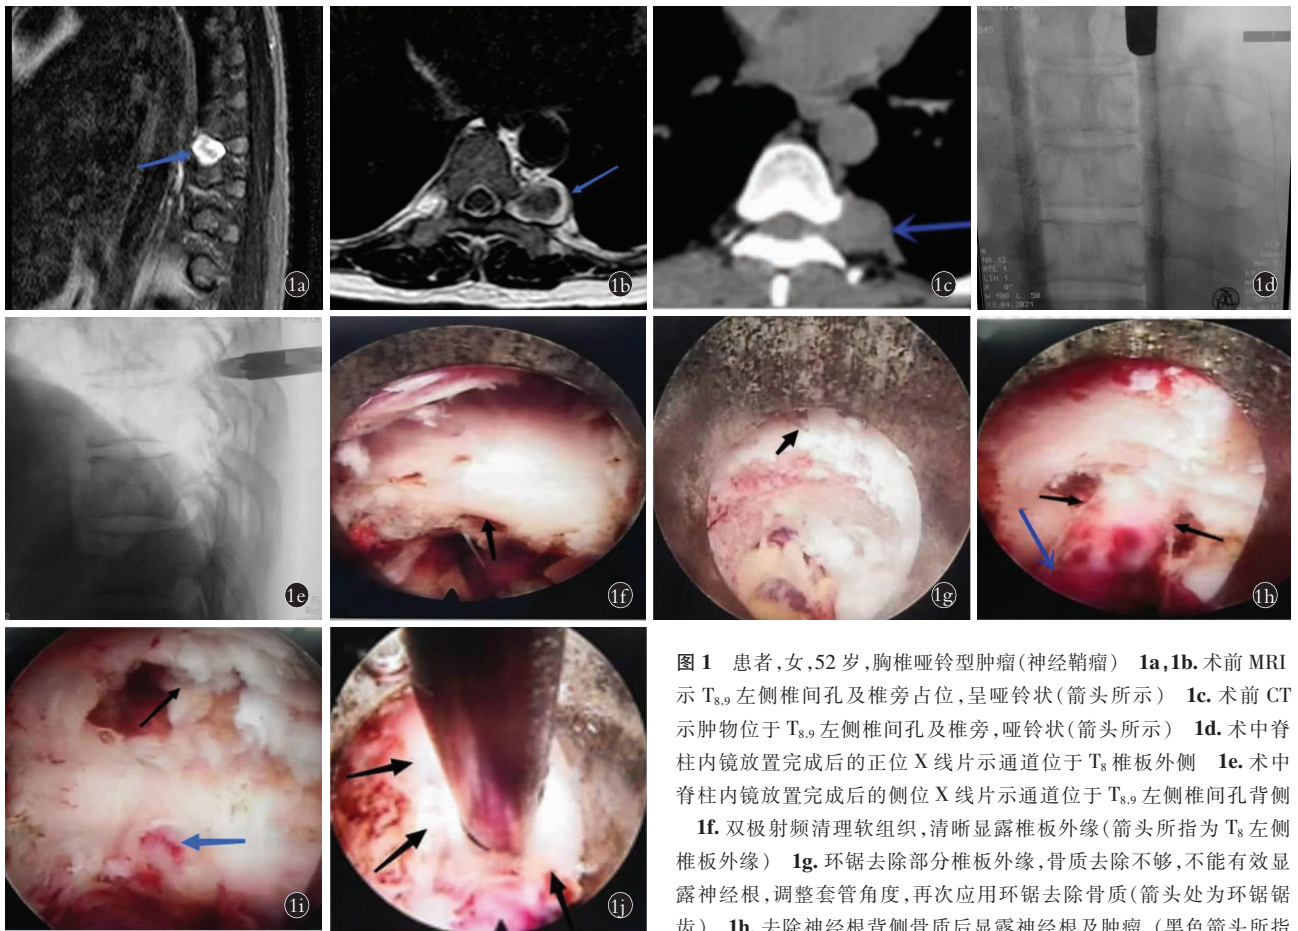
患者,女,52 岁,胸椎哑铃型肿瘤(神经鞘瘤) 1a,1b. 术前 MRI 示 T_{8,9} 左侧椎间孔及椎旁占位,呈哑铃状(箭头所示) 1c. 术前 CT 示肿物位于 T_{8,9} 左侧椎间孔及椎旁,哑铃状(箭头所示) 1d. 术中脊柱内镜放置完成后的正位 X 线片示通道位于 T₈ 椎板外侧 1e. 术中脊柱内镜放置完成后的侧位 X 线片示通道位于 T_{8,9} 左侧椎间孔背侧 1f. 双极射频清理软组织,清晰显露椎板外缘(箭头所指为 T₈ 左侧椎板外缘) 1g. 环锯去除部分椎板外缘,骨质去除不够,不能有效显露神经根,调整套管角度,再次应用环锯去除骨质(箭头处为环锯锯齿) 1h. 去除神经根背侧骨质后显露神经根及肿瘤(黑色箭头所指为神经根,蓝色箭头所指为神经根远端的肿瘤组织) 1i. 切断神经根(黑色箭头所指为神经根近侧断端,蓝色箭头所指为神经根远侧断端) 1j. 切断神经根后予神经断端处填塞可吸收明胶海绵(箭头所示白色部分为可吸收明胶海绵)
